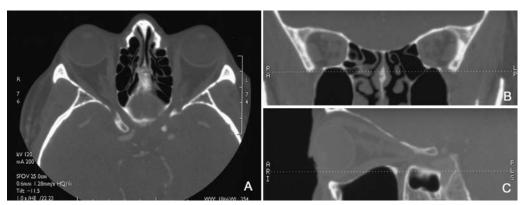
Bone windows: (A) normal axial CT, (B) normal coronal reconstruction, and (C) normal sagittal reconstruction.
